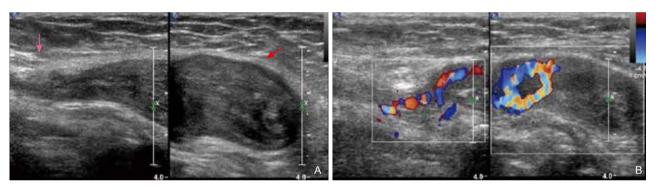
(A) Sagittal sonogram of the right inguinal region shows a fusiform hypoechoic mass (red arrow) with stalk-like structure (pink arrow) at the cranial pole of the mass; (B) Color Doppler sonogram shows scattered blood flow signals in the mass.
